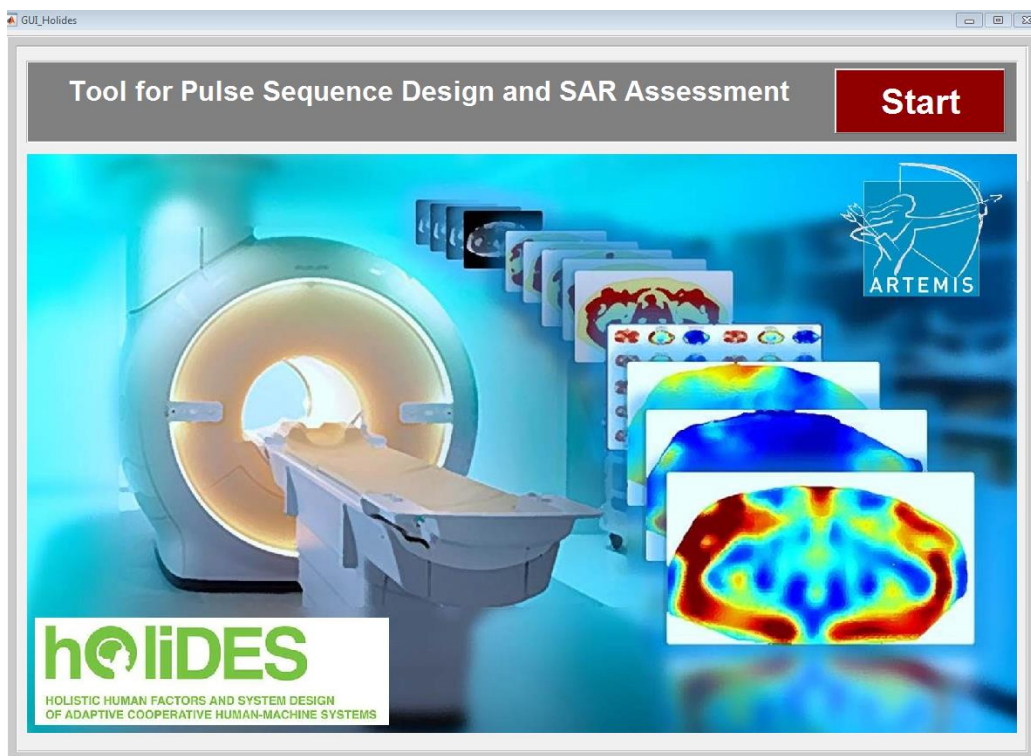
Front page' of the software tool for safe parallel transmit MRI
